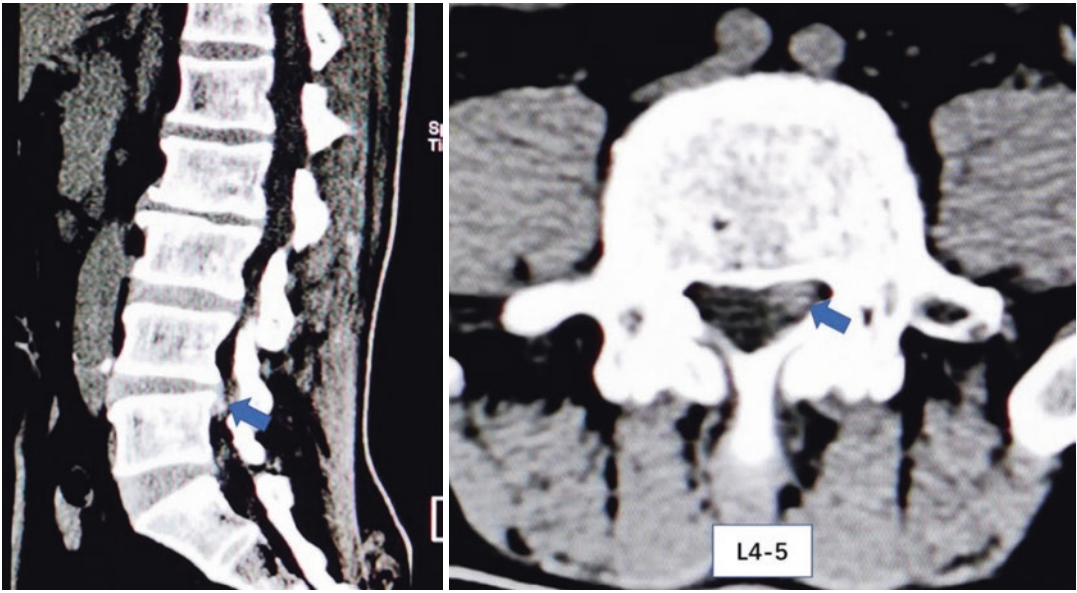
Preoperative CT scan showed LDH on the L4-5 left side
